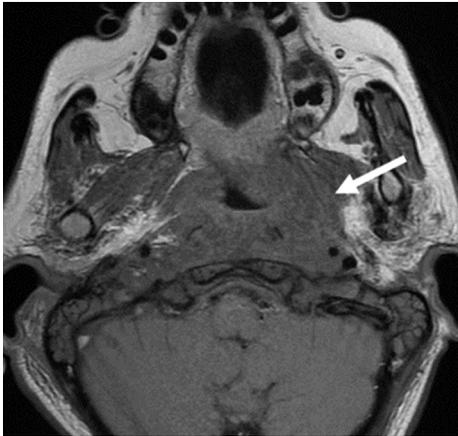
Parapharyngeal extension (arrow) of the NPC on Axial T1-weighted image showing posterolaterally and laterally penetration through the levator palatini muscle and pharyngobasilar fascia and involvement of the tensor palatini muscle and parapharyngeal fat space.
